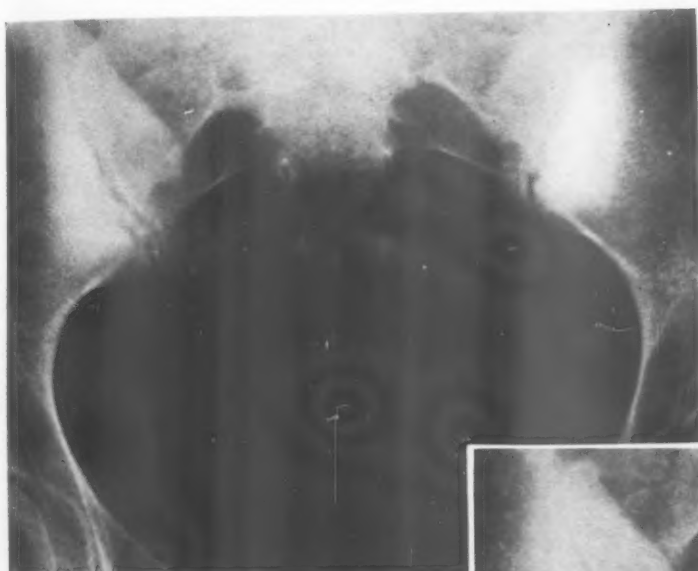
Case 14, female aged 31 years, radiograph taken in 1945 considered to be osteitis condensans ilii.
